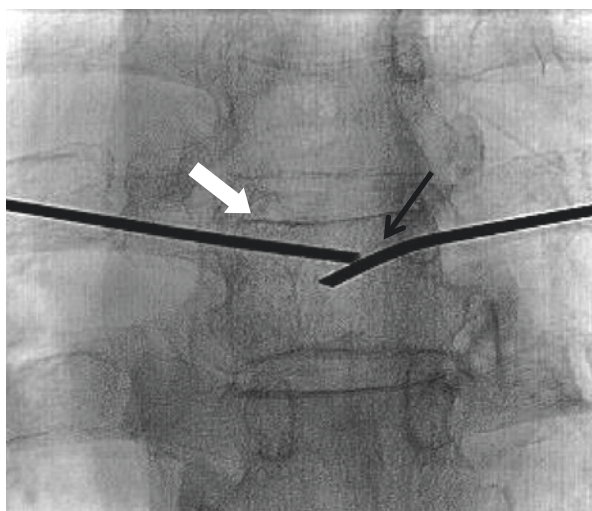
Same patient that in Fig. 8.5 (aggressive hemangioma in the D5 already treated with hemilaminectomy), AP radiograph: trocar positioning for VPL (*black arrow*) in the soma (15G) and trocar (15G) carrying (*white arrow*) the microcatheter (Echelon) for percutaneous embolization of epidural component of hemangioma
